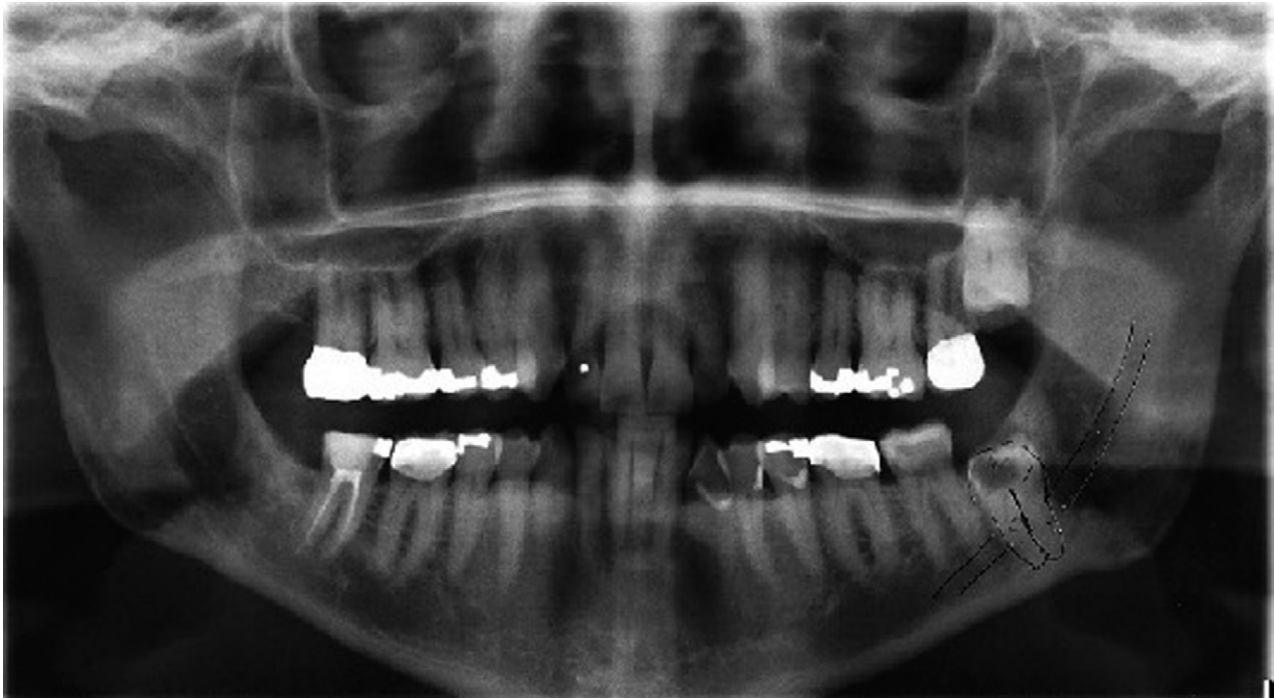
Panoramic radiograph displaying a vertically oriented and carious impacted mandibular left third molar.
